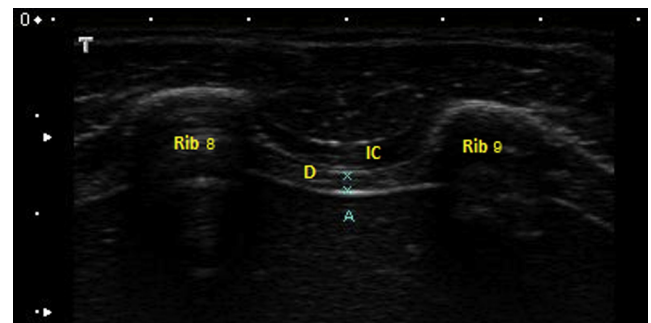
Representative ultrasound image of the diaphragm at EELV. The x notations along the hyperechoic line represent the electronic caliper with the A distance being 1.5 mm. D = diaphragm; IC = intercostal muscles; A = abdominal muscles; EELV = end-tidal expiratory lung volume.
